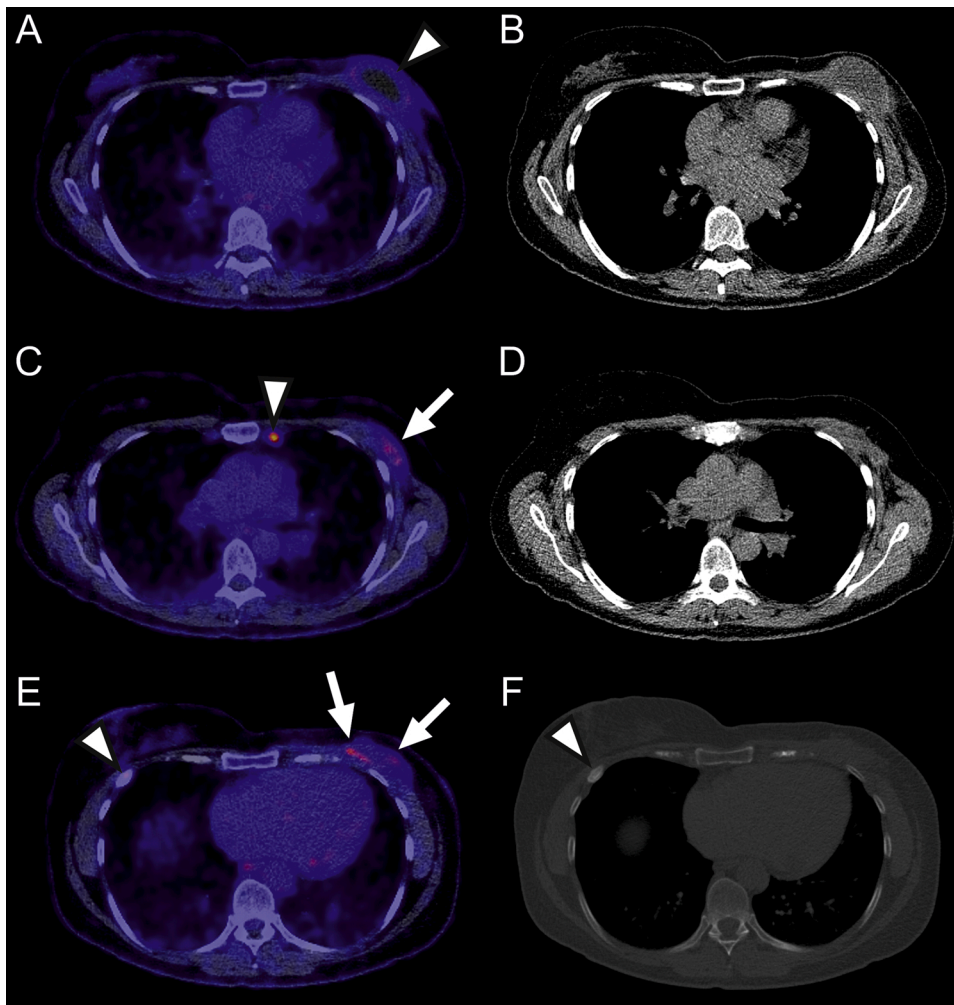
A 47-year-old woman with a history of breast cancer and mastectomy, and focally increased uptake in several ribs on recently performed bone scintigraphy (not shown). Low-dose FDG-PET/CT was performed to evaluate for metastatic disease. Axial fused FDG-PET/CT (A, C, E) with corresponding low-dose CT (B, D, F) slices at three different levels are demonstrated. FDG-PET showed slight FDG uptake around the breast prosthesis (A, arrowhead), but also high FDG uptake in the soft tissues in the left axilla (C and E, arrows) and in a left internal mammary lymph node (C, arrowhead), and focally increased FDG uptake in a right-sided rib (E, arrowhead), which were interpreted as recurrent metastatic breast cancer in the original report. However, before FDG-PET/CT it was already known that the breast implant was leaking and that there was an inflammatory reaction in the surrounding tissues. This information was available in the patient's clinical records, but not in the request form for FDG-PET. Based on this information, the increased FDG uptake in the soft tissues in the left axilla and in the left internal mammary lymph node were likely attributable to the leaking breast implant. Furthermore, low-dose CT showed callus formation in the right-sided rib with increased FDG uptake (F, arrowhead), suggestive of fracture. Three-year follow-up did not show any signs of metastatic disease. These cognitive errors were corrected with an addendum 7 days after authorization of the original report.
